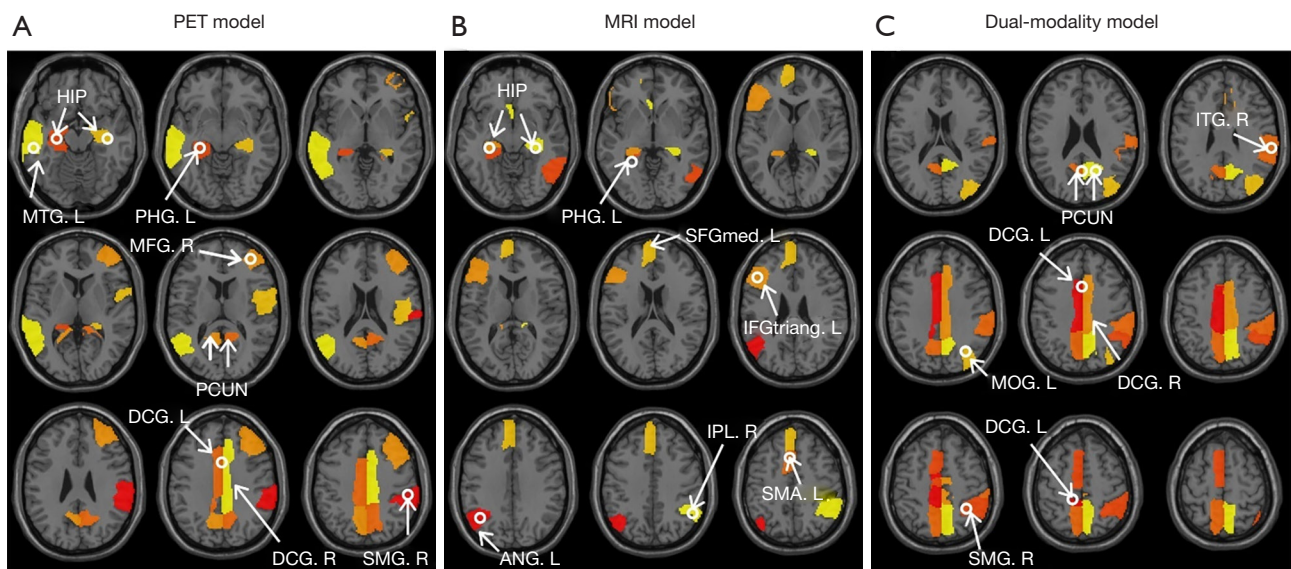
The different brain regions of the features conserved by different radiomic models: (A) the radiomic PET model, (B) the radiomic MRI model, (C) the dual-modality model. PET, positron emission tomography; MRI, magnetic resonance imaging; L, left; R, right; MTG, middle temporal gyrus; HIP, hippocampus; PHG, parahippocampal gyrus; MFG, middle frontal gyrus; PCUN, precuneus; DCG, median cingulate and paracingulate gyrus; SMG, supramarginal gyrus; SFGmed, superior frontal gyrus, medial; IFGtriang, inferior frontal gyrus, triangular part; IPL, inferior parietal; SMA, supplementary motor area; ITG, inferior temporal gyrus; MOG, middle occipital gyrus.
